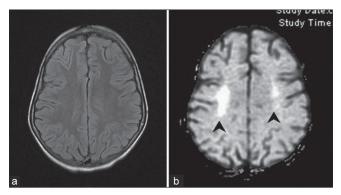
FLAIR- (a) and diffusion-weighted image (b) from the initial study shows areas of restricted diffusion in the deep white matter in the region of centrum semiovale (arrowheads). The corresponding areas on the FLAIR image are normal
